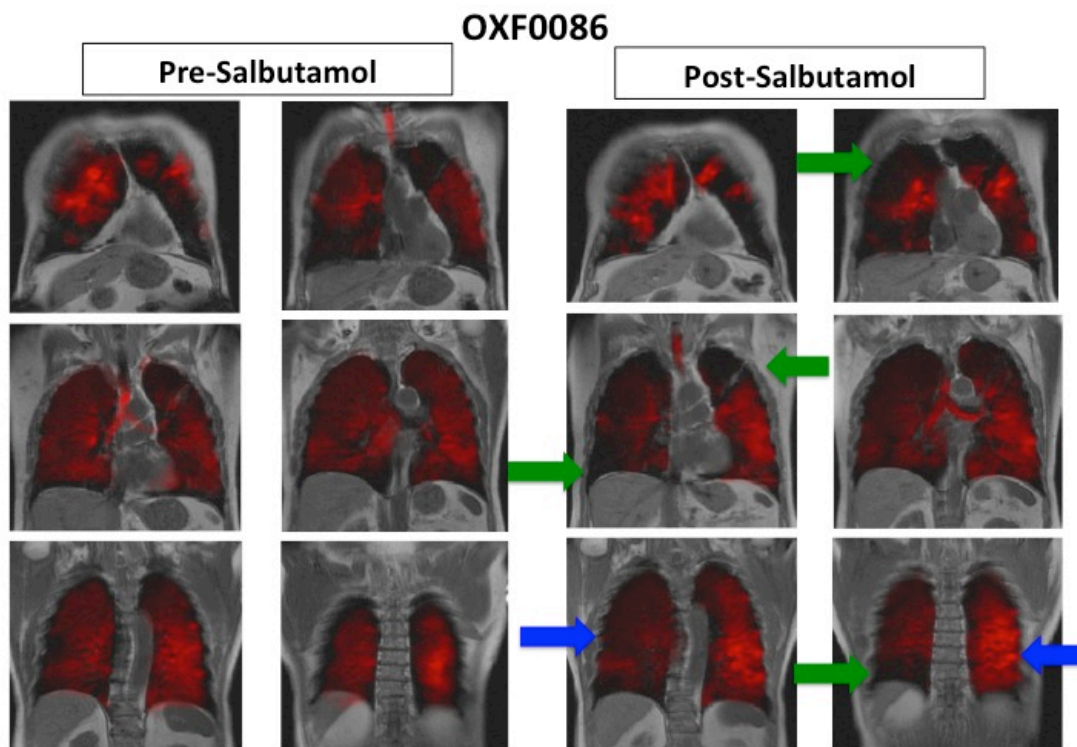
Coronal co-registered HP ¹²⁹Xe-MR ventilation and proton MR imaging acquired in OXF0086 pre- and post-salbutamol. The blue arrows indicate improvement in right mid zone and left lower zone ventilation signal intensity post-salbutamol. The green arrows indicate new ventilation defects in the left upper, right upper and right lower zones post-salbutamol.
